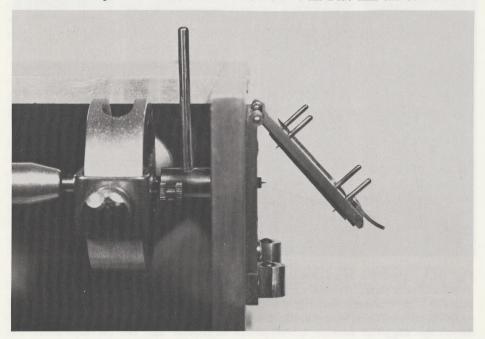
3. The point of the actual rotation axis can be recorded on the x-ray film from the medial side by means of an extension on the axis shaft of the articulator. When the cover is closed 4 small pins perforate the x-ray film.
